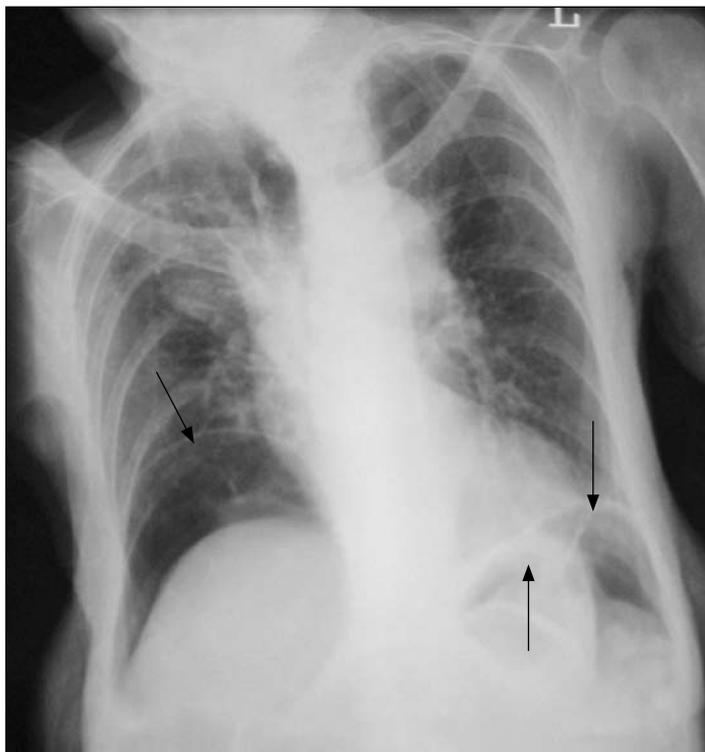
Chest X-ray showing gas under the diaphragm. The white arrows indicate the raised left and right hemidiaphragms. The gastric bubble is indicated by the black arrow
